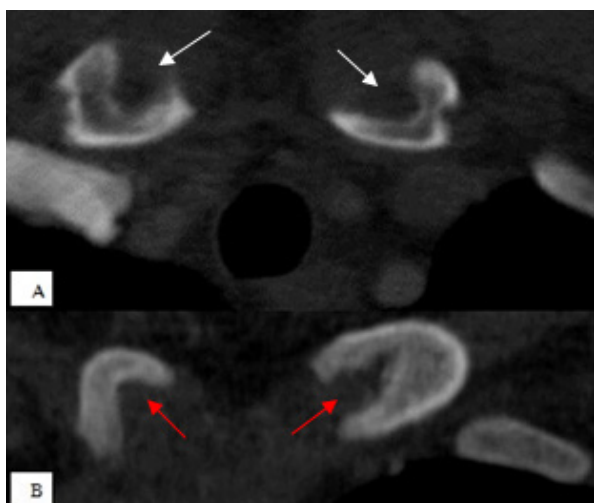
(A, B) CT images of medial clavicles. A significant notching is seen on the heads of both clavicles on the axial image (A, white arrows) and the coronal image (B, red arrows). The epiphyseal ossification center is not visible
